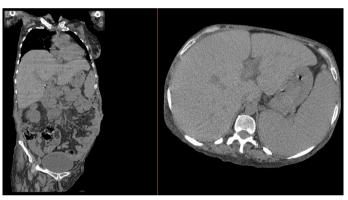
Abdominal computed tomography revealed hepatosplenomegaly and free fluid in the abdomen.
